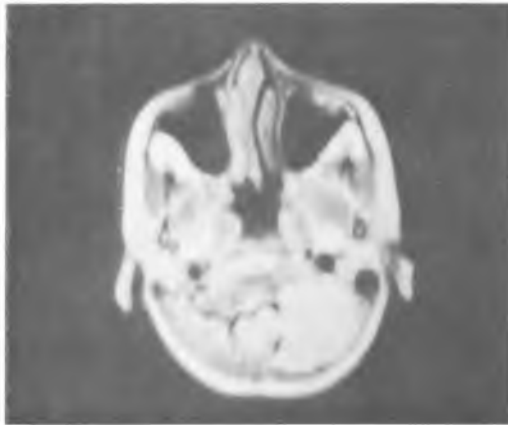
A man B. D. 45 years. Postcontrast axial CT scan. The tumour mass with irregular outlines and increased density in the region of left pontocerebellar angle is seen. It penetrates into the left middle cranial fossa and infiltrates the region of left thalamus and posterior part of the third ventricle. There is a widening of ventricular system and displacement of fourth ventricle backwards and to the right side. There is no evident contrast enhancement of tumour mass. Micronodular calcifications within tumour mass are seen. Chordoma was found at operation
